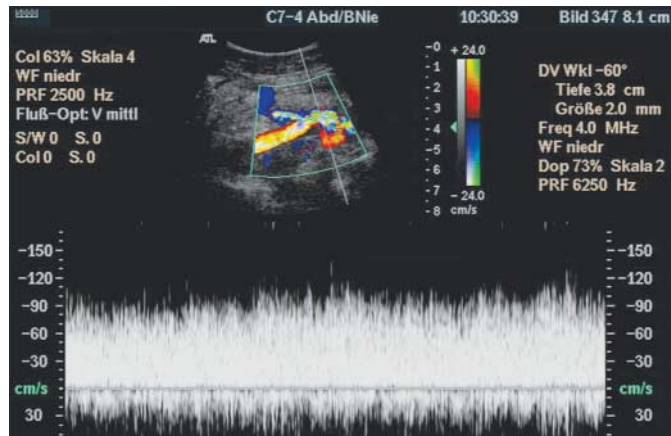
Colour coded duplex sonography of the renal transplant vein: high flow velocities and turbulent flow in the vein in the area of the crossing with the iliac artery and at the site of the anastomosis with a peak velocity of 120 cm/s.
